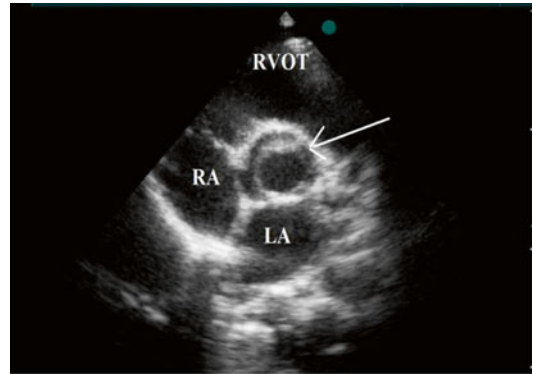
Oval-shaped opening of the bicuspid aortic valve (BAV) in parasternal short-axis view; note the evaluation was done in systole (arrow). LA left atrium, RA right atrium, RVOT right ventricular outflow tract (Video 35.1)
